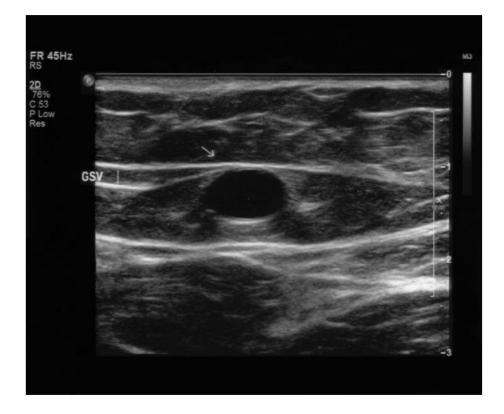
Transverse ultrasound image of the great saphenous vein. The great saphenous vein lies in a subcompartment bordered superficially by the saphenous fascia and deeply by the muscular fascia. [17]
